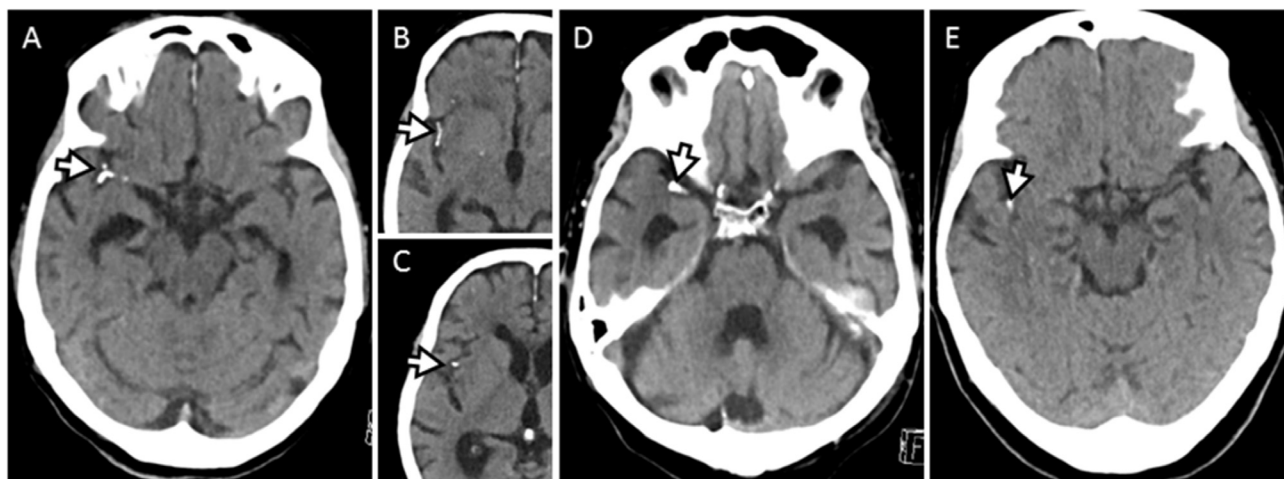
Calcified emboli in acute ischemic stroke on native brain CT. Closed black arrows showing calcified intravascular material in the middle cerebral arteries on the right side in all patients. Panel A-C: Patient 1, D: Patient 2, E: Patient 3.
